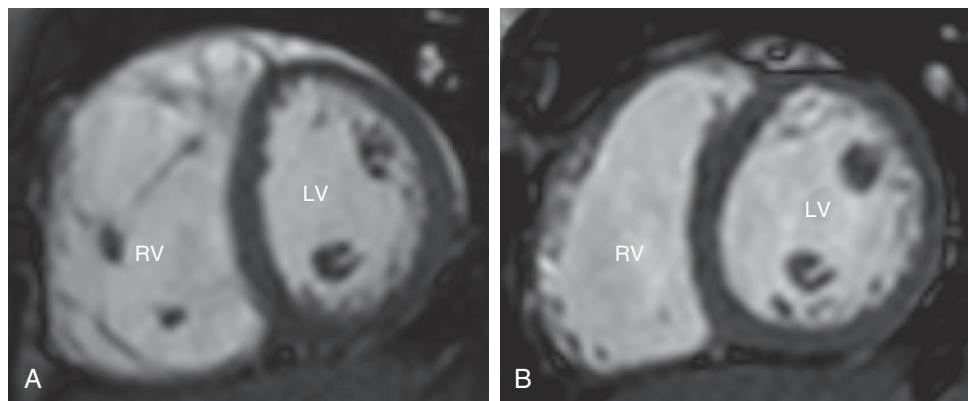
■ A, Cine magnetic resonance image in the short-axis plane in the same patient as shown in Figure 131-2 demonstrates severe right ventricular (RV) dilation with a preoperative RV end-diastolic volume of 150 mL/m². B, Repeat imaging in the same patient performed 1 year after surgical closure demonstrates decreased RV end-diastolic volume to normal at 80 mL/m². LV, Left ventricle.
